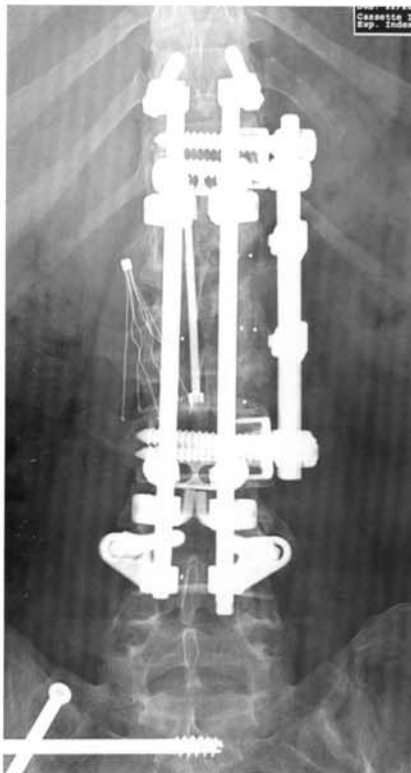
Plain film radiograph – AP view – At one year follow-up, plain films demonstrate excellent alignment has been maintained and a solid fusion has occurred.
